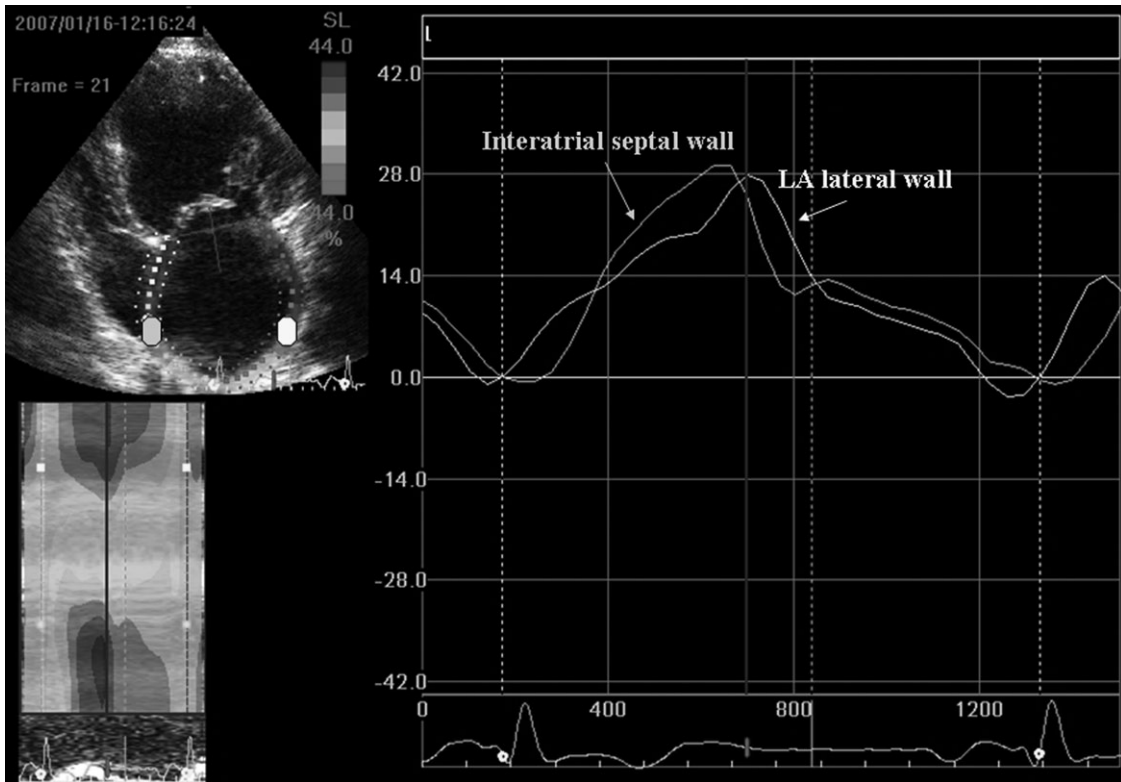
Longitudinal two-dimensional strain curves of basal left atrial lateral wall and basal interatrial septal wall in a patient with ischaemic dilated cardiomyopathy from an apical four-chamber view. The curves are colour coded by the defined myocardial segment as depicted in the figure (yellow, basal lateral wall; gray, basal interatrial septal wall). Note that the impairment of LA deformation is less severe than in the idiopathic patient (peaks of systolic strain of 32% and of 28%, respectively). See Supplementary material online for a coloured version of this figure.
